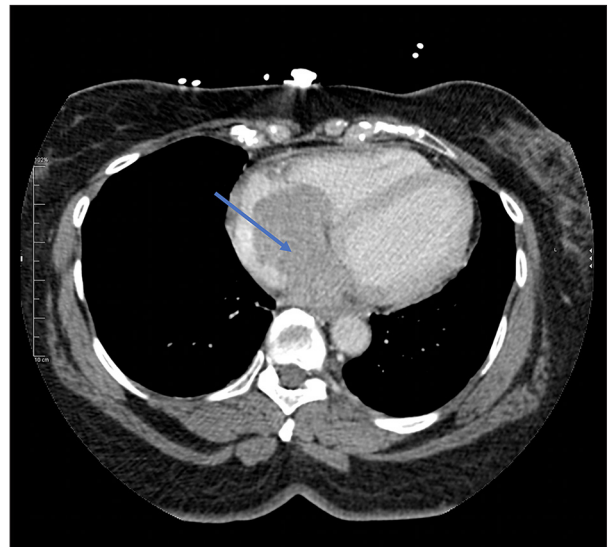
Computed tomography scan with transverse view. There is a right atrial mass with partial obstruction of the tricuspid valve (arrow).
